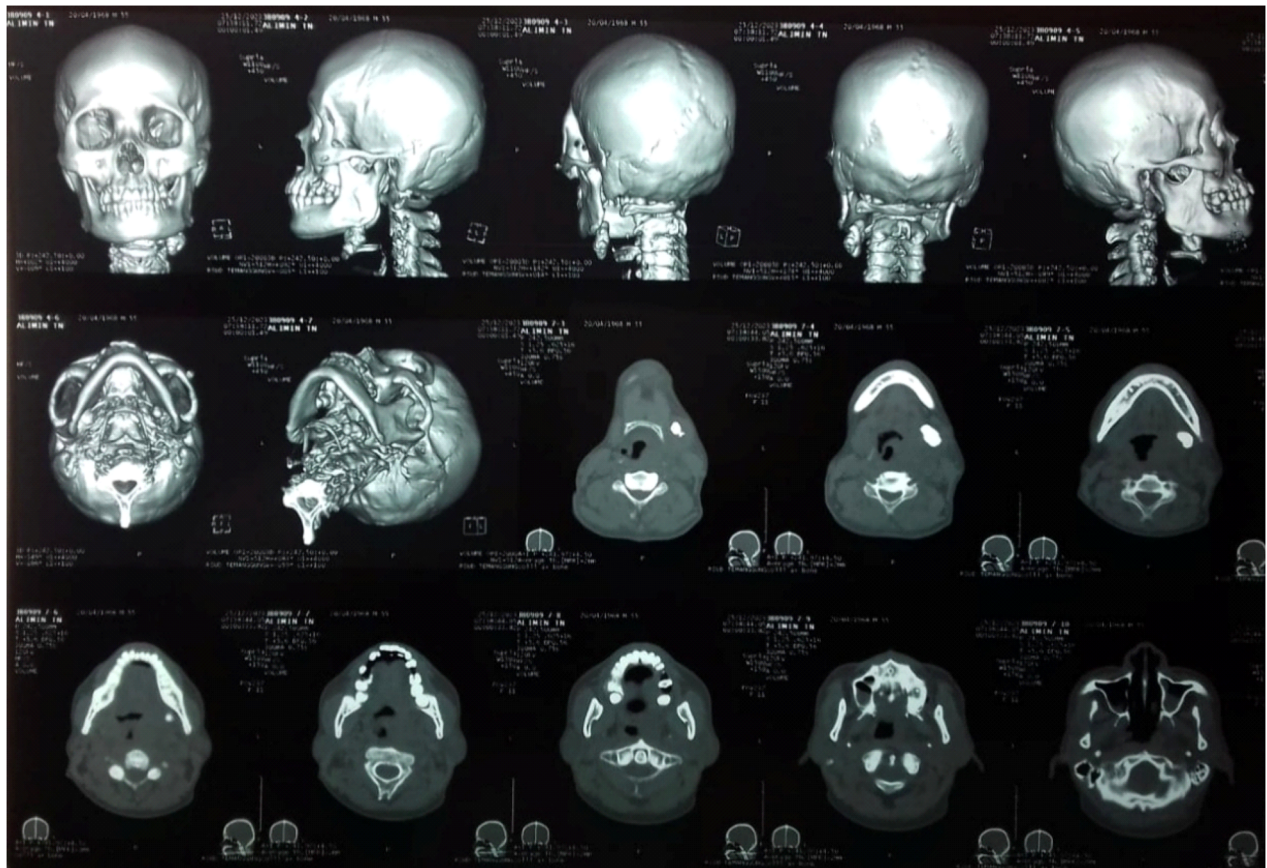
Multi-slice computed tomography revealed a hyperdense mass surrounded by hypodense shadow, reflecting the presence of stones in the duct of the left submandibular gland.
